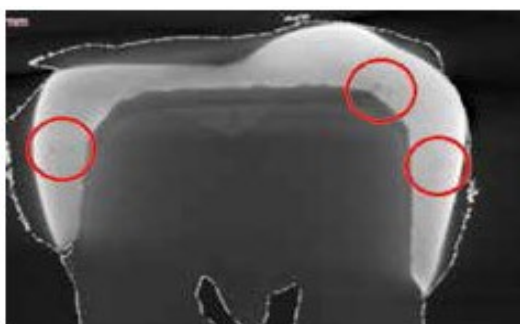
X-ray of an SLM-printed crown showing porosities [24].
